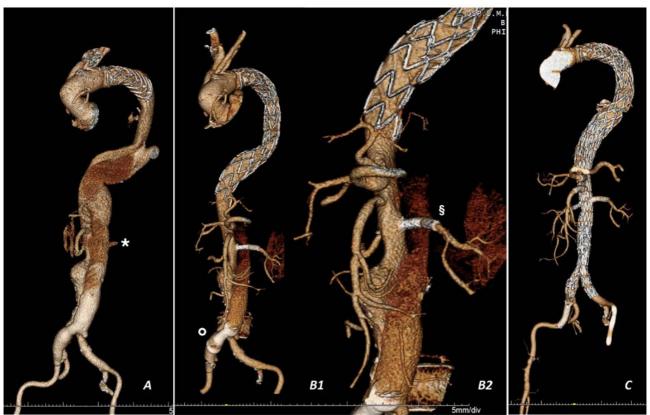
Patient 17. Fig. 1.A: 3D-CT 3 years after Ascending + arch replacement with Frozen
